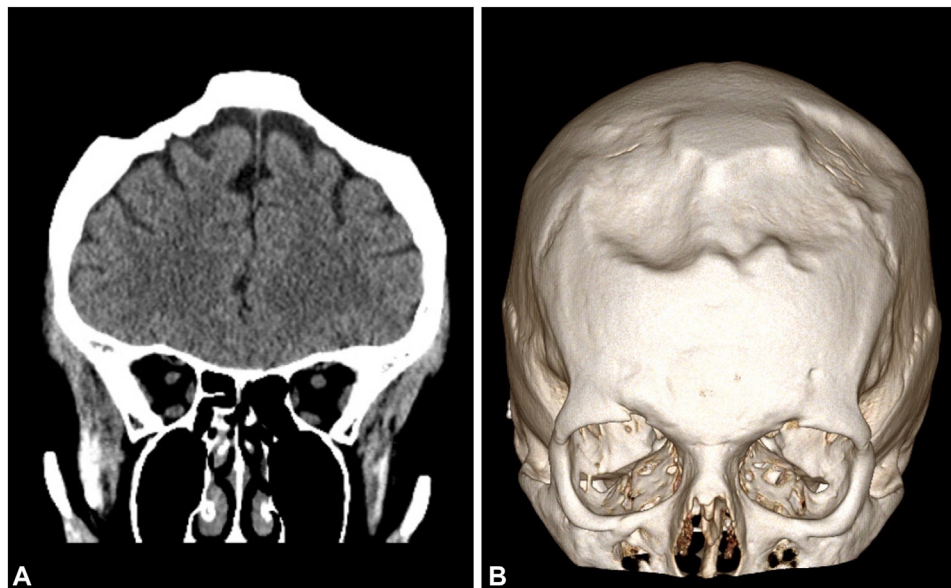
Frontal bone loss. A, Coronal view of the computed tomography (CT) brain demonstrating thinning of bilateral frontal bones along with bilateral scalp atrophy about the vertex. B, Three-dimensional reconstruction of the CT brain without contrast reveals a smoothly margined concave deformity of the bilateral frontal calvarium.
